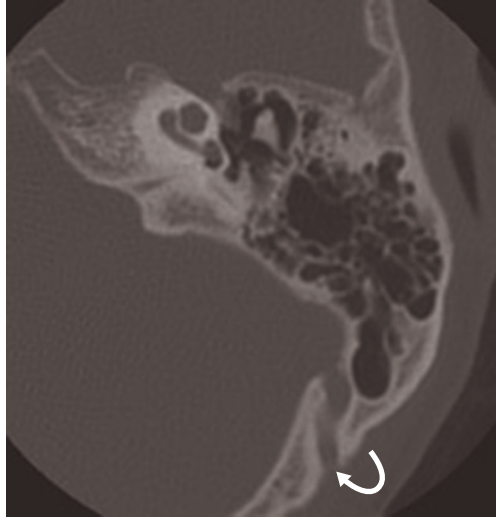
Axial CT scan. Large mastoid emissary vein (arrow).
